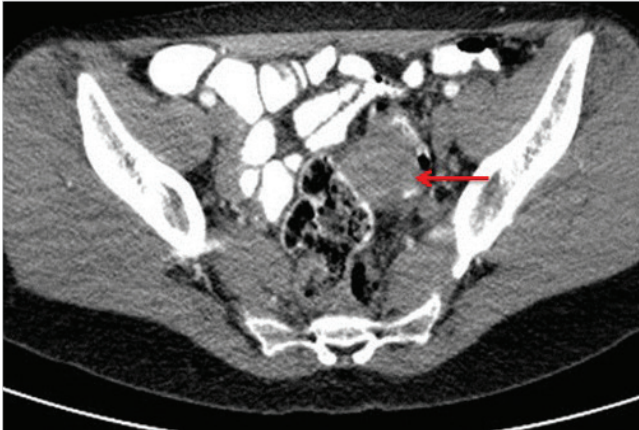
Axial contrast-enhanced CT shows a mass lesion in the rectosigmoid region. The mass is indiscernible from intestinal wall, it is mildly enhanced by I.V. contrast agent, and it causes no obstruction.
